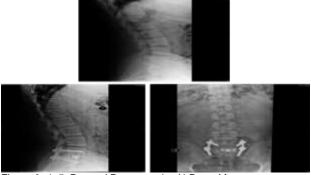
Pre and Postoperative X-Rays After
